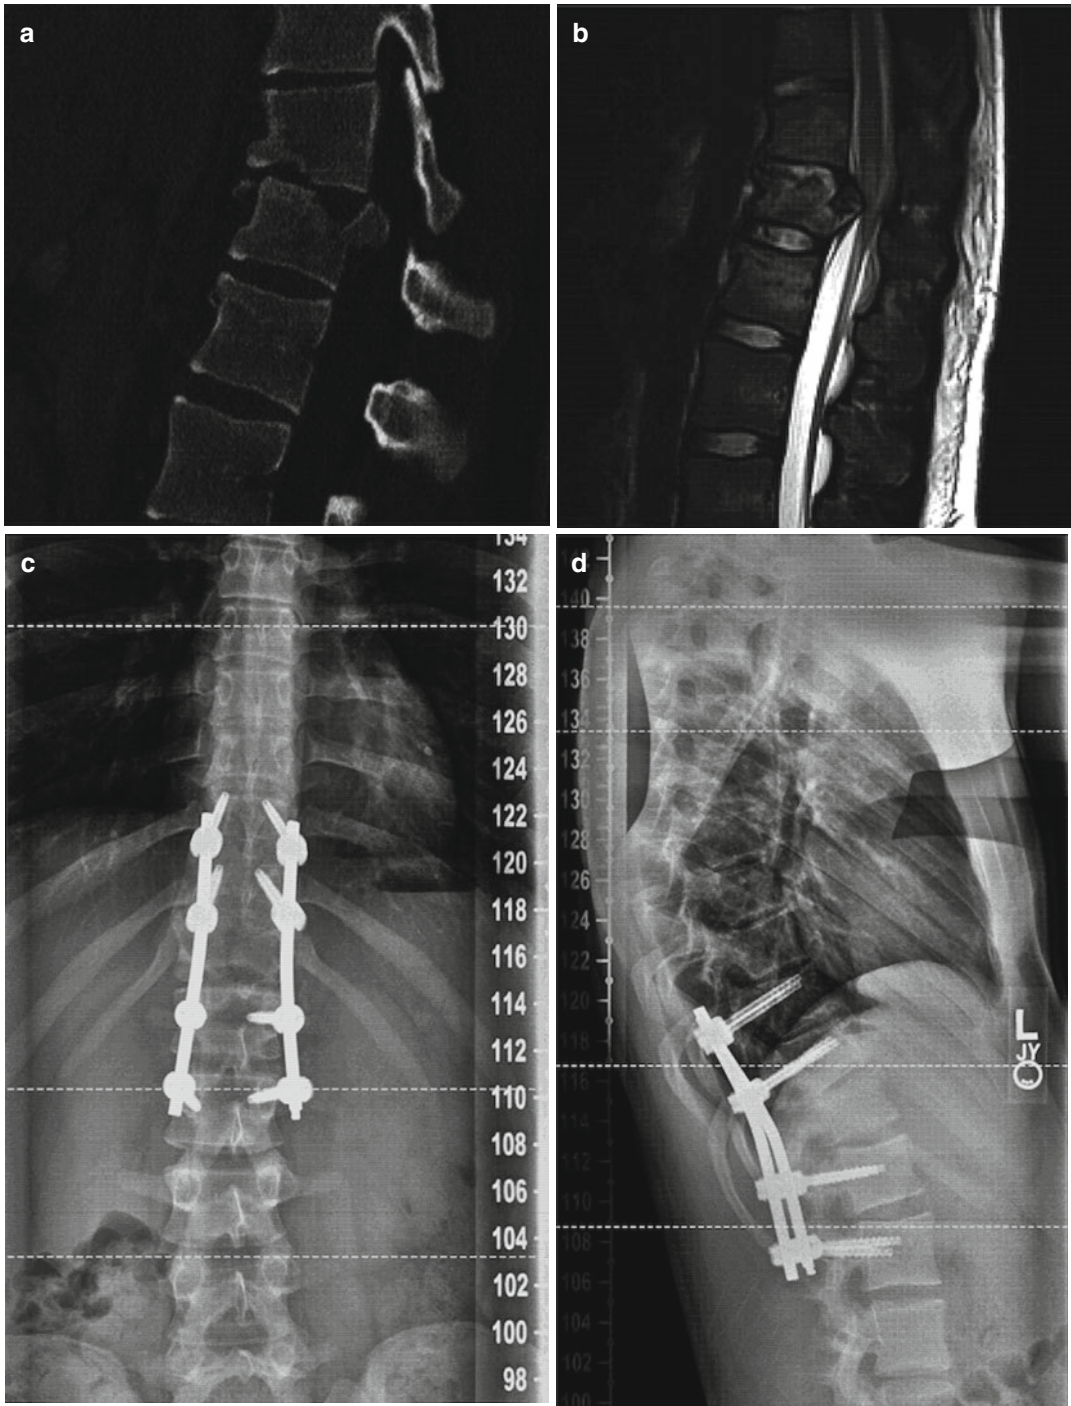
Sagittal CT scan (a) demonstrating a burst fracture involving the T12 vertebral body with focal kyphosis and loss of the disk space at the T11–T12 level. There is retropulsion of a 1.3 × 1.0 cm fragment from the T12 vertebral body into the spinal canal. Sagittal T2-weighted MRI (b) demonstrating focally increased T2 signal intensity
